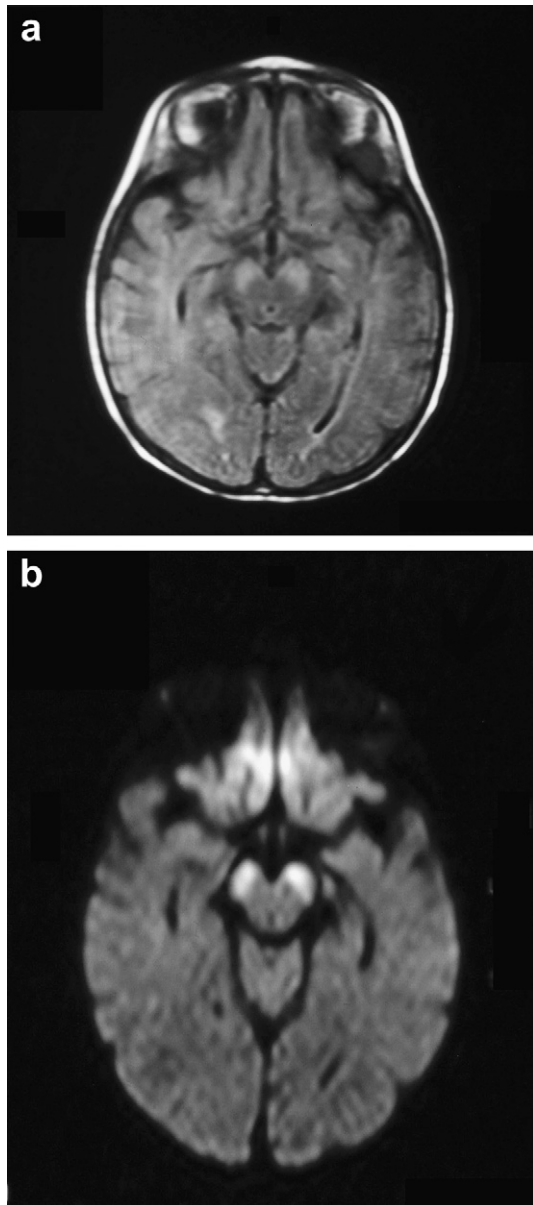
(a) Axial FLAIR image and (b) axial diffusion-weighted image of patient 4 showing bilateral increased signal in the cerebral peduncles (crus cerebri and substantia nigra).
